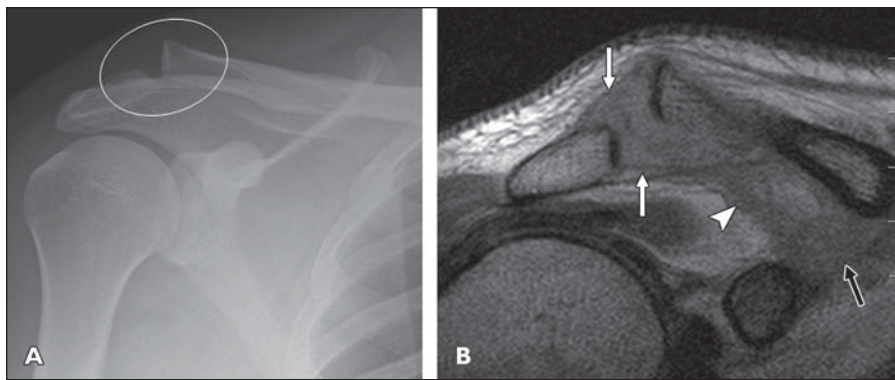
29-year-old man after right-sided acromioclavicular joint injury with suspected radiographic Rockwood type II injury reclassified Rockwood type IV at MRI. A, Anteroposterior radiograph shows 60% superior displacement of clavicle and accentuated acromioclavicular interspace (*ellipse*). B, Coronal proton density-weighted image (TR/TE, 1500/25) shows disruption of acromioclavicular ligaments (*white arrows*), coracoclavicular ligaments (*black arrow*), and coracoacromial ligament (*arrowhead*) with diffuse subclavicular soft-tissue swelling. Normal ligamentous anatomy is abolished. Continuity of clavicle is not fully visible.
